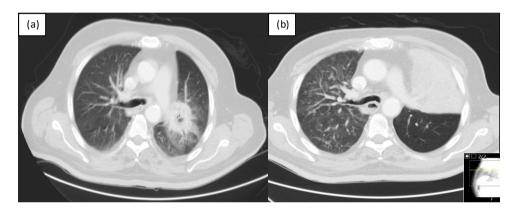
(a) and (b) CT of the chest revealing a lesion with a necrotic center in the left upper lobe, previously to surgery and CT of the chest after surgery.
